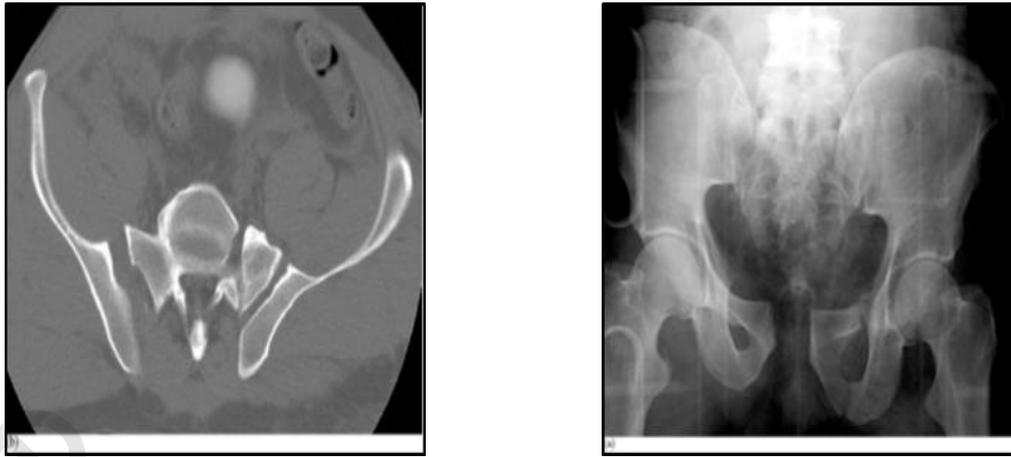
(a) AP radiograph shows greater than 2.5 cm symphysis Diastasis. The posterior SI joints are likely intact, but the anterior right SI joint looks wide; (b) axial CT image demonstrates right anterior SI diastasis and small avulsion fracture of left anterior SI joint indicating anterior ligament injury on this side (c) axial CT image of symphysis diastasis. This Tile B1 fracture is rotationally unstable, but vertically stable. <sup>(33)</sup>
